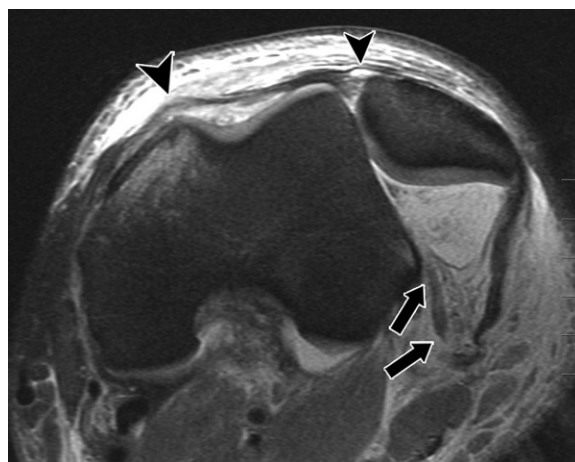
Patellofemoral dislocation in the setting of severe multitrauma in a 22-year-old man who sustained multiple injuries in a motor vehicle accident. He presented with an unreduced patellofemoral dislocation in the setting of a complex multiligament knee injury. Axial PD-weighted fat-suppressed MR image shows that the patella is dislocated laterally, with irregularity and abnormal signal intensity in the medial retinaculum (arrowheads) near its patellar insertion and at its midsubstance. There is also tearing of the lateral retinaculum posteriorly (arrows).
